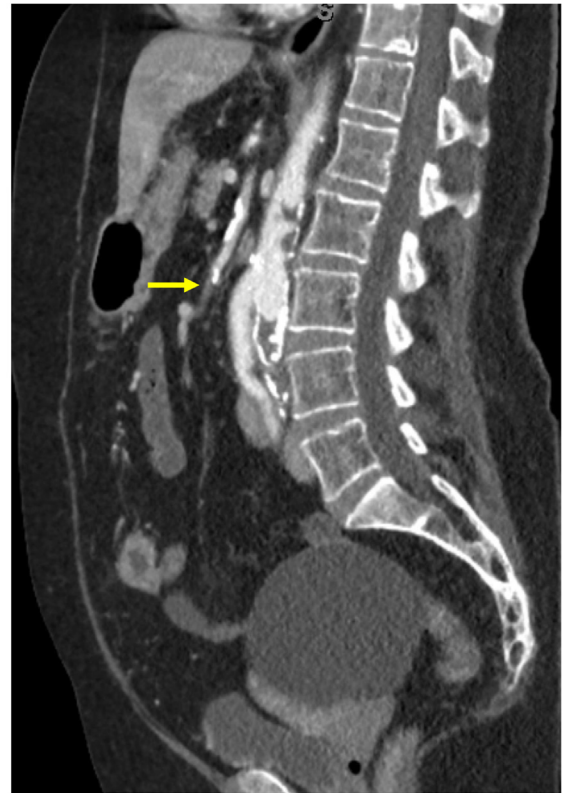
Sagittal computed tomography angiography (CTA) image showing superior mesenteric artery (SMA) occlusion (arrow).
